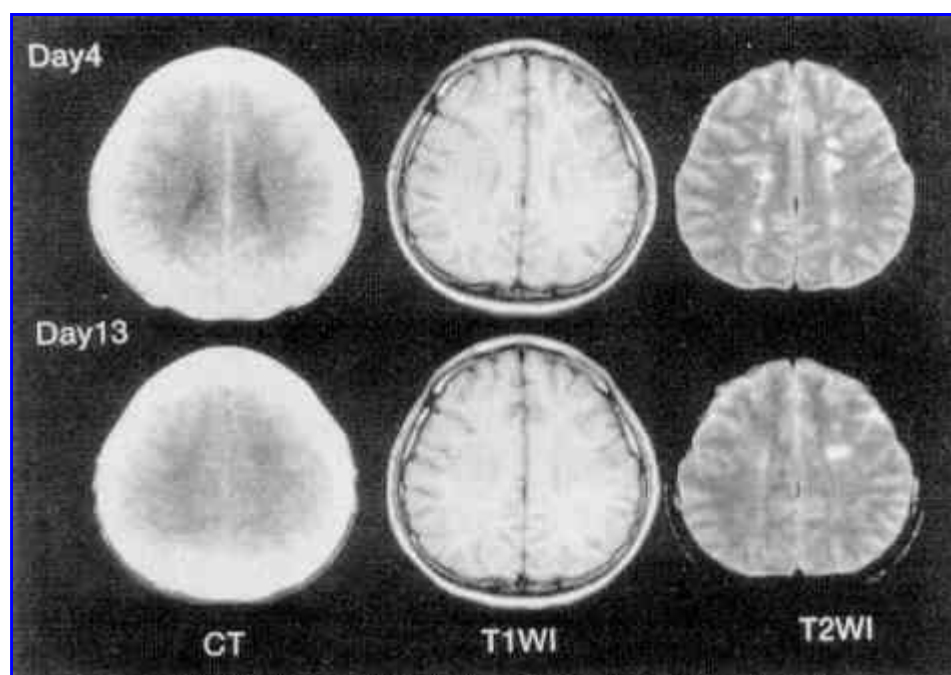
Neuroimaging in case 5. CT scan images, MRI-T1WI, and MRI-T2WI. T2WI performed on day 4 after onset of neurologic symptoms (upper right) shows high-intensity lesions in the cerebral deep white matter (MRI grade 2). T2WI obtained at day 13 when the patient became alert (lower right) demonstrates resolution of the high-intensity areas to MRI grade 1. However, the CT scan and T1WI reveal no detectable abnormalities during the entire follow-up period.
